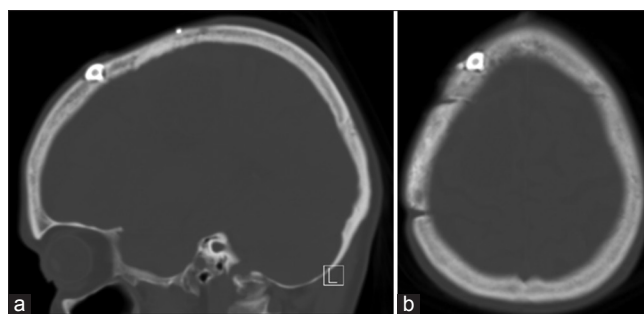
Coronal (a) and axial (b) section of computed tomography scan demonstrating the placement of the ommaya reservoir in the bony recess of the skull through the outer table and the diploic layer up to the inner table
